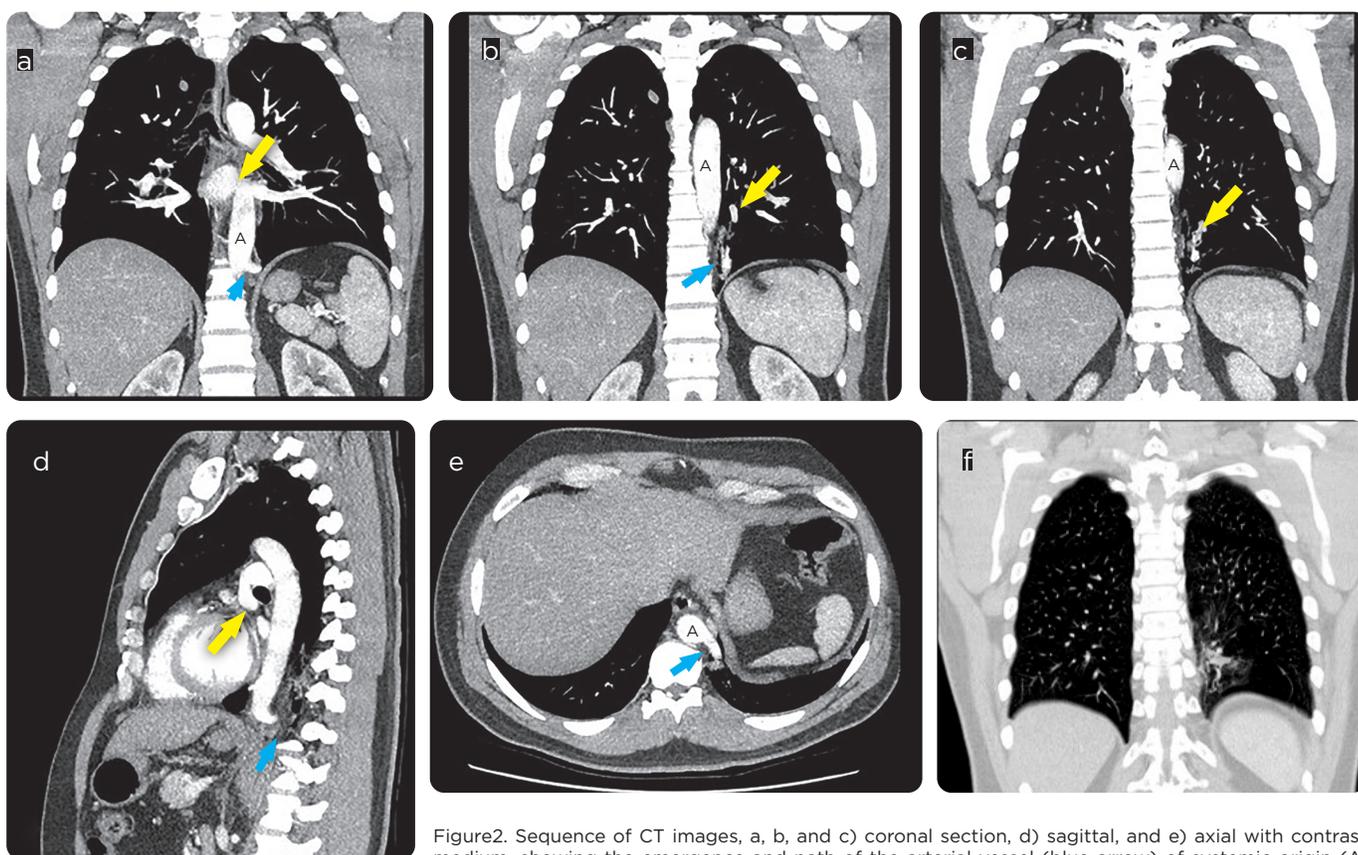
Sequence of CT images, a, b, and c) coronal section, d) sagittal, and e) axial with contrast medium, showing the emergence and path of the arterial vessel (blue arrow) of systemic origin (A: thoracic aorta) and the venous drainage a (yellow arrow) pulmonary veins. f) Image in coronal section window for lung showing alveolar type infiltrates in the parenchyma.
